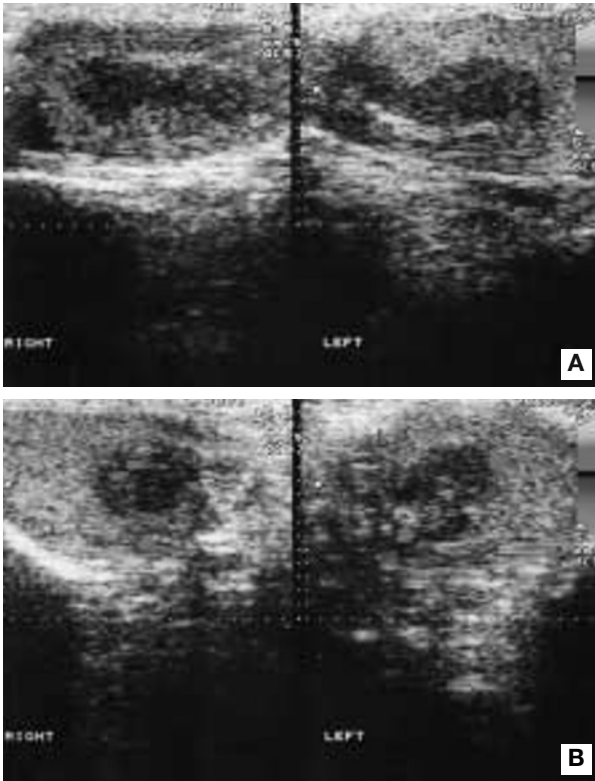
Longitudinal (A) and axial (B) sonograms of the right and left testes show bilateral hypoechoic lesion close to the mediastinum testis with poor vascularity in the peripheral portions of the lesions.
